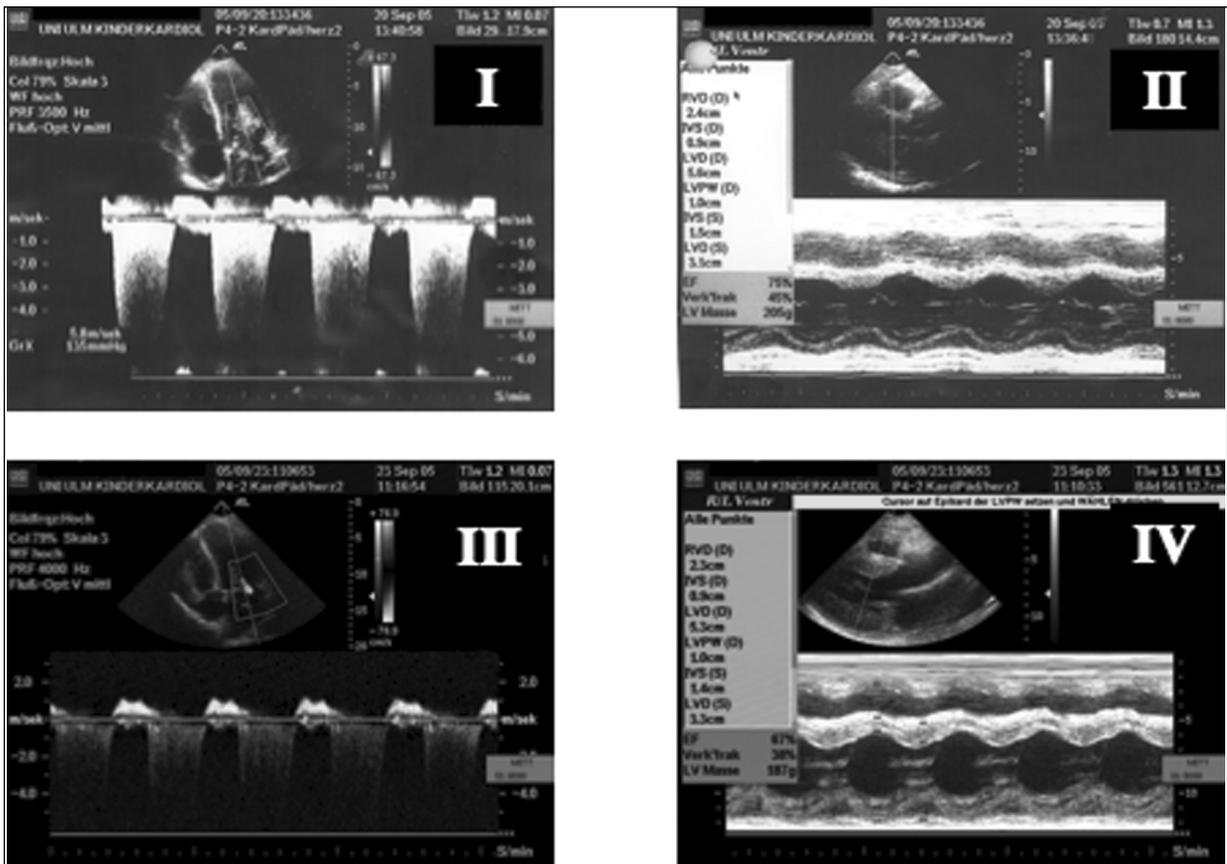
Doppler echocardiographic assessment of mitral valve regurgitation in an apical view (Case 1) showing moderate mitral valve regurgitation as a sign of acute heart failure (I). Measurements of left ventricular function and dimension at the end of systole and diastole by M-mode echocardiography in a parasternal long-axis view, showing enlargement of the left ventricle and impairment of the left posterior wall motion as signs of acute heart failure (II). Almost normal findings in the control assessments after 5 days (III/IV).
